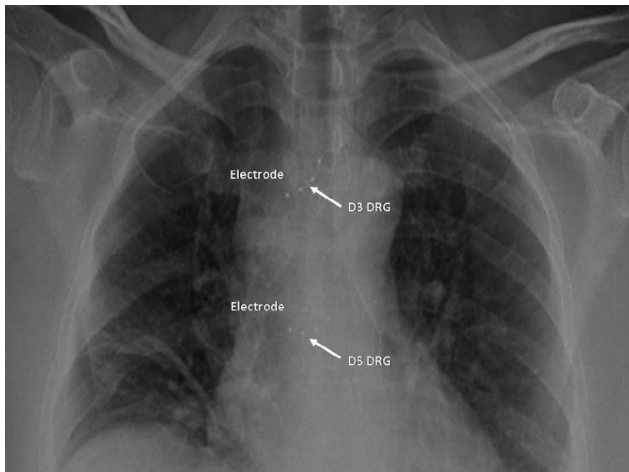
Thoracic radiograph with anterior-posterior view demonstrating DRG-S lead placement at the third and fifth dorsal (thoracic) levels.
